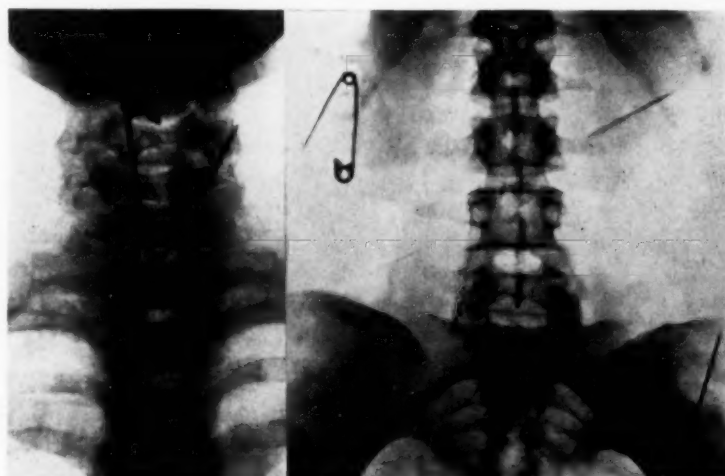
(A and B.) Roentgenograms from the nasopharynx to the tuberosities of the ischium showing (a) safety pin in the upper esophagus; (b) safety pin, a needle and a common pin in the abdomen. The pin in the esophagus was removed esophagoscopically. The safety pin and pin in the abdomen passed by bowel, but
